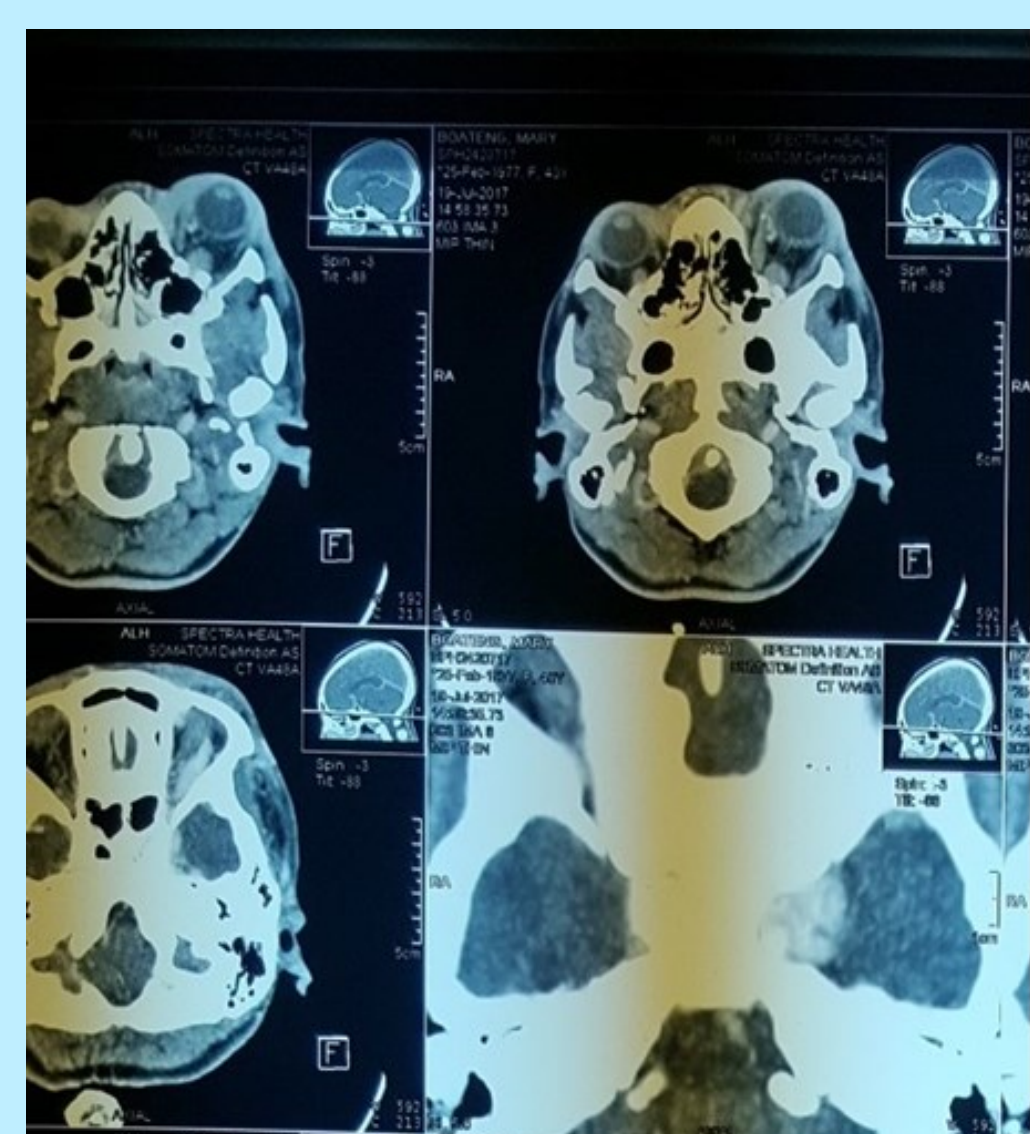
Axial view of CT scan showing proptosis of left eye ball
